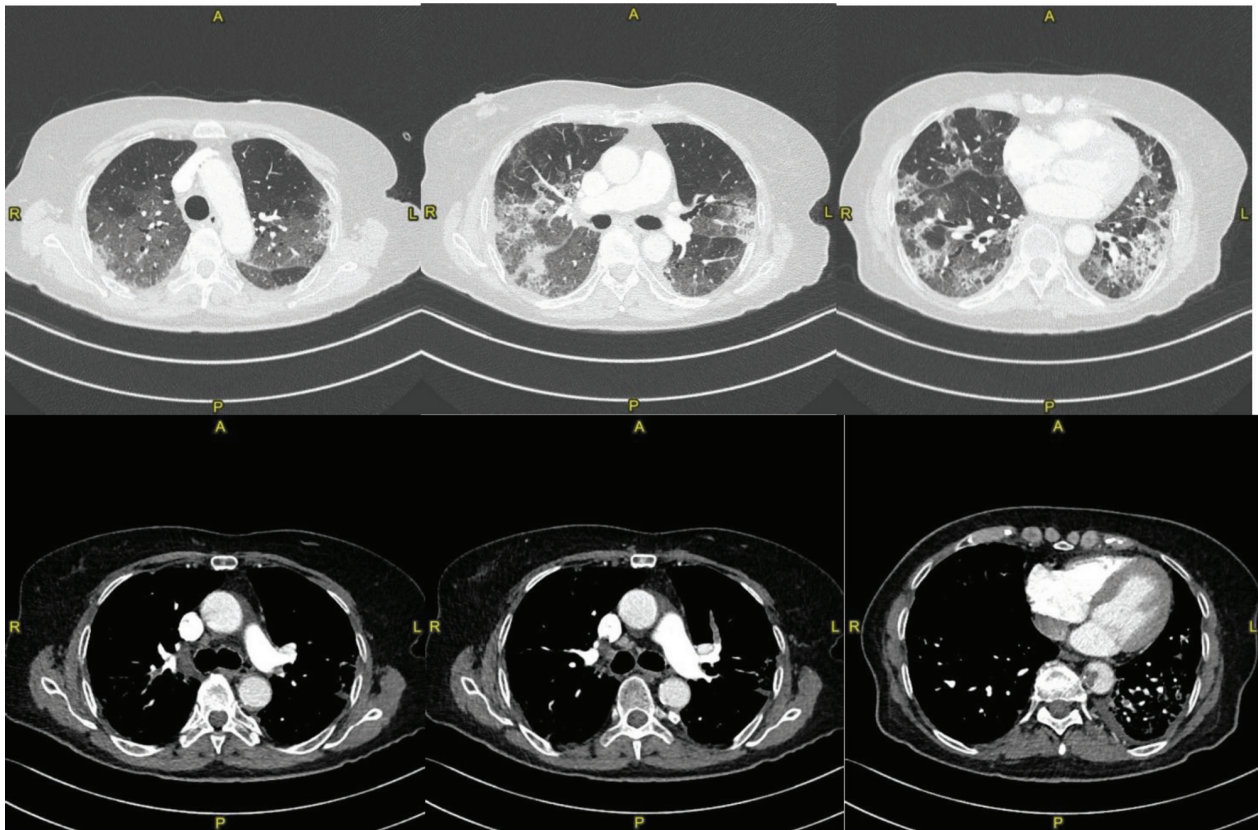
CT scan after worsening gas exchange (April 2020): Bilateral segmental pulmonary embolism involving the branch for the posterior segment of the right upper lobe, anterior segmental branch of the left upper lobe and the branch for the dorsal segment of the left lower lobe. Worsening of ground glass opacities (visual score of 60%).
